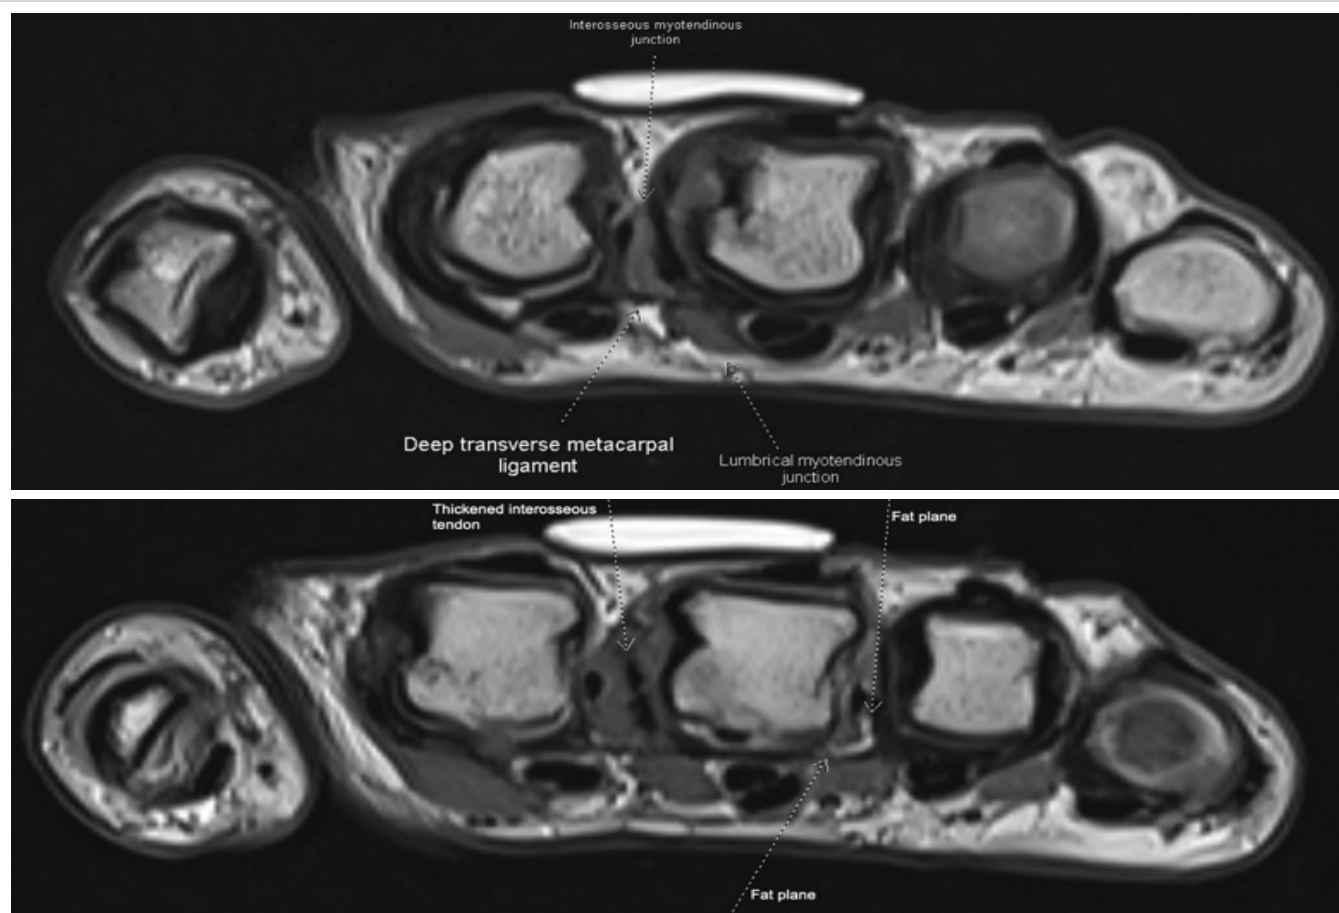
(a) Axial proton density magnetic resonance imaging images at the level of the second metacarpal head. Notable is the absence of fat plane between the interosseous musculature (dorsal second interspace) and the volar deep transverse metacarpal ligament (DTML), with blurring of the lumbrical-interosseous border along the ulnar aspect of the DTML. Thickening of the interosseous tendon is evident compared to more proximal levels. (b) Axial images 3 mm proximal to the previous image in Figure 1a. In comparison, the third interspace shows a fat plane between the interosseous and lumbrical musculature. The second interspace demonstrates a thickened interosseous tendon, particularly on the ulnar aspect.
